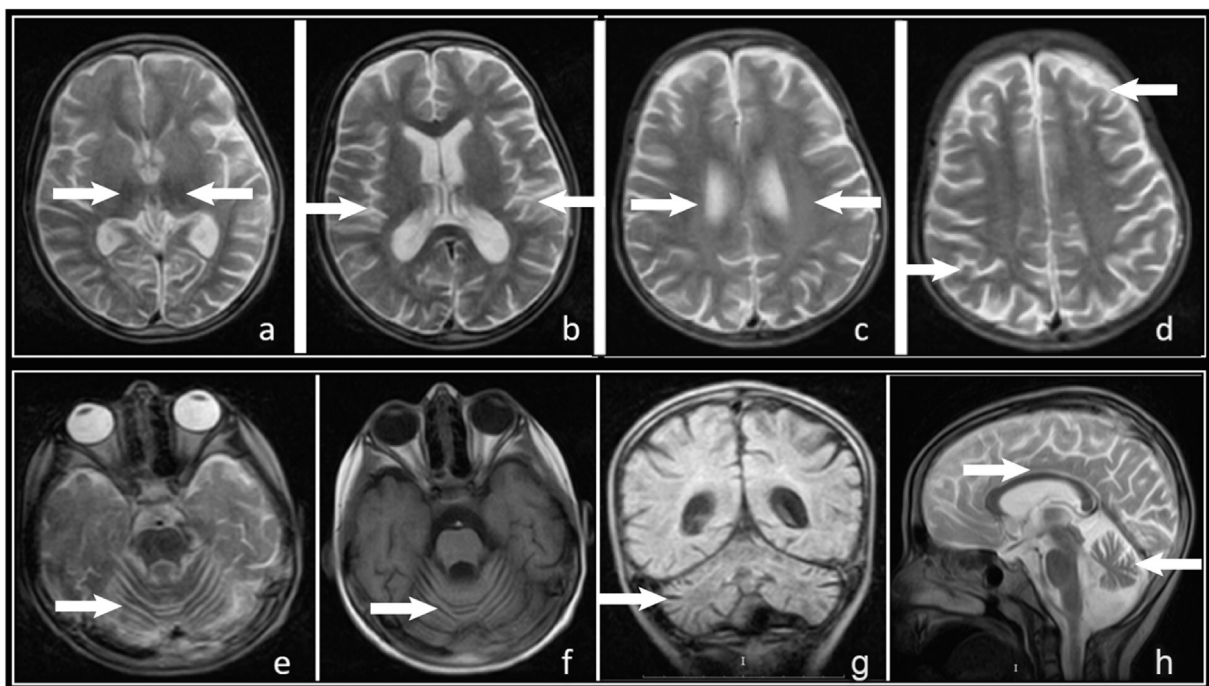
Patient 6 – MRI scan taken 2 years after the onset of symptoms. Significant progression of linear hyperintensity of central white matter is highlighted (c). This figure also reveals significant progression of thalamic hypointensity (a), cerebellar atrophy (e, f, g, h) and cerebral atrophy (b, d) that was not seen on the MRI scan taken 1 year earlier.
